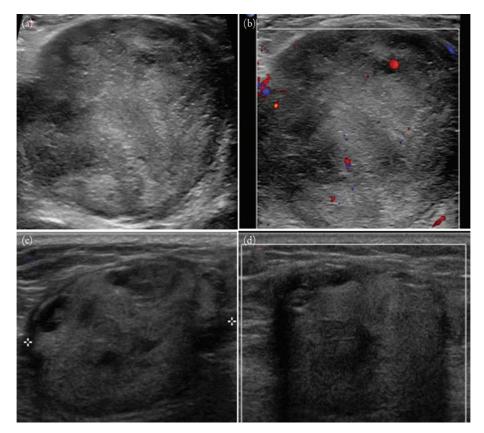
Sarcoma on ultrasound. Panels (a) and (b), respectively, show grayscale and color Doppler images in transverse plane of a solid-appearing soft tissue mass with heterogeneous echogenicity. The mass has internal flow on Doppler interrogation. A malignant soft tissue tumor must be excluded. Panels (c) and (d), respectively, show another soft tissue mass with heterogeneous echogenicity. There is no flow seen in this lesion with color Doppler. The absence of color Doppler signal in a solid appearing soft tissue mass does not exclude a malignant soft tissue mass. Both of these masses are biopsy proven soft tissue sarcomas.
